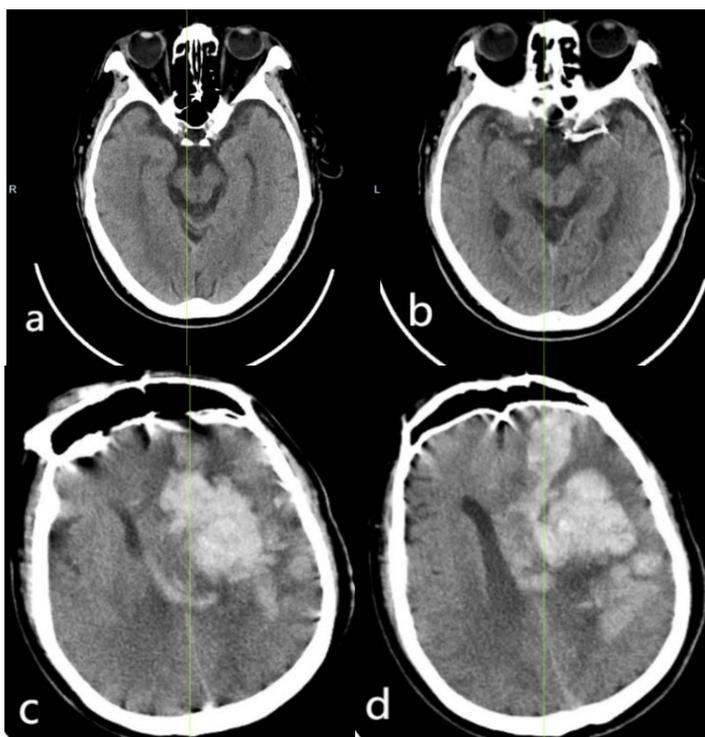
(a) and (b) show the CT scan on the first day after right middle cerebral artery stent implantation in the patient, indicating that the stent was well implanted and no other abnormalities were found in the intracranium. (c) and (d) show the follow-up CT scan on the fourth day after stent implantation, and the patient suffered a fatal cerebral hemorrhage
